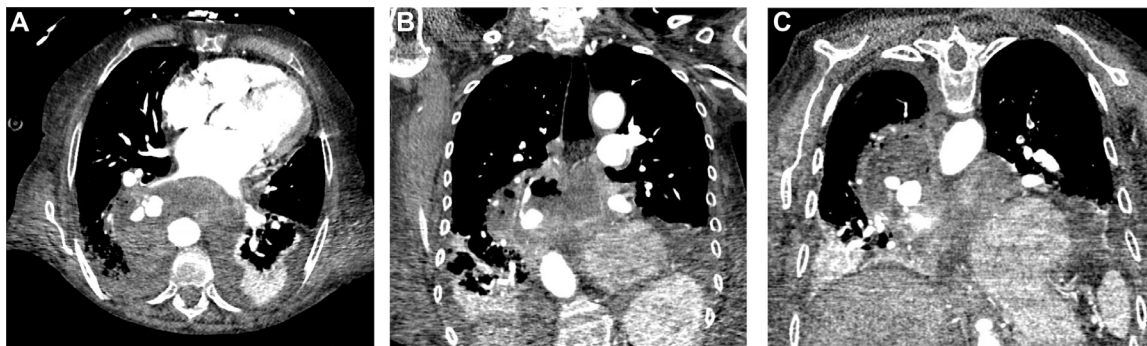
Axial (A) and coronal (B, C) contrast-enhanced CT images demonstrating the site of esophageal rupture (arrows) and adjacent PAPs (arrowheads).
